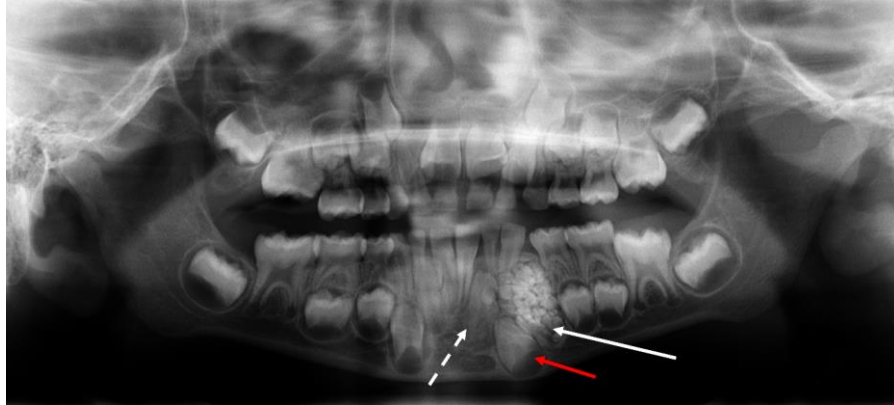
Panoramic X-ray. White arrow: compound odontoma between teeth n°73 and n°74. Eruption delay of tooth n°32 compared to tooth n°42 (white dashed arrow). Eruption delay of tooth n°33 compared to tooth n°43 due to the odontoma obstacle on the eruption pathway (red arrow). Superimposition of the compound odontoma on the apex of the root of tooth n°73.
